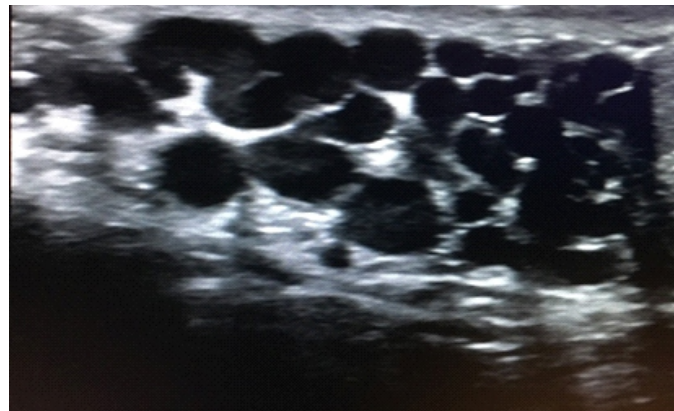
Ultrasound (Pre-treatments, varicocele grade 4)
